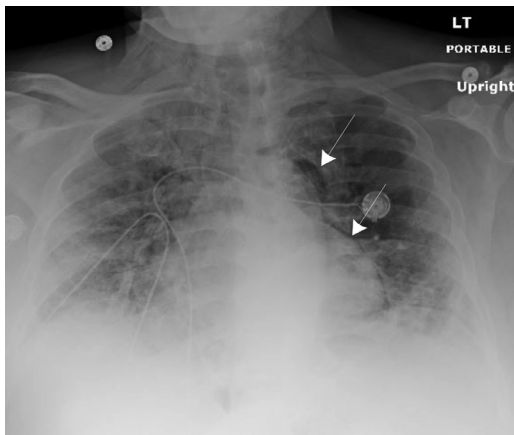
Chest x-ray revealing a crescent of air that outlines the ascending aorta and also the left border of the heart consistent with pneumomediastinum (white arrow), that is tracking to the lower neck, and supraclavicular regions.
